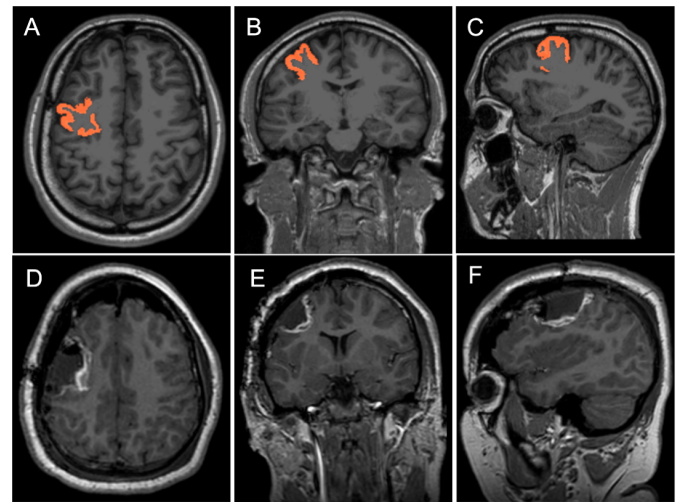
Comparison between the preoperative and postoperative MRI scans. The highlighted region refers to the Caudal Middle Frontal (cMFG).
